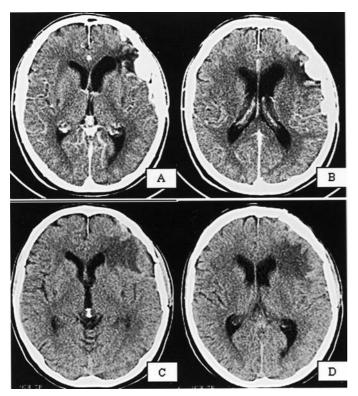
CT scan with contrast enhancement showing preoperative aspects of meningiomas in A and B. Postoperative examination demonstrating a complete removal of the tumour in C and D
